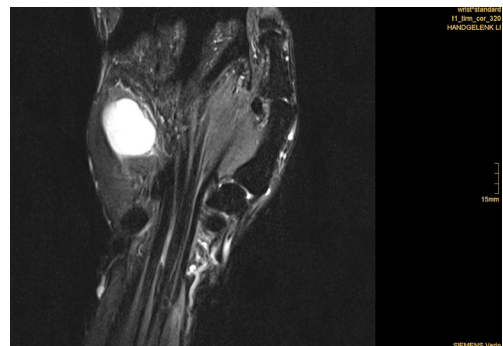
Soft tissue tumor with a hyperintense T2 magnetic resonance imaging signal.
